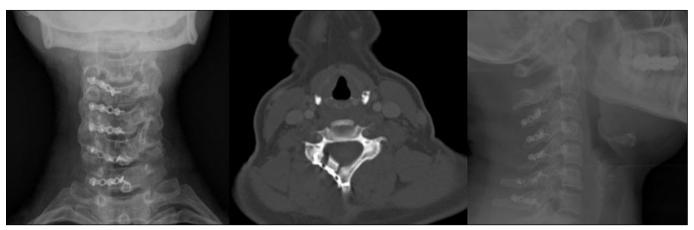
Postoperative 12th month roentgenogram and computed tomography.
